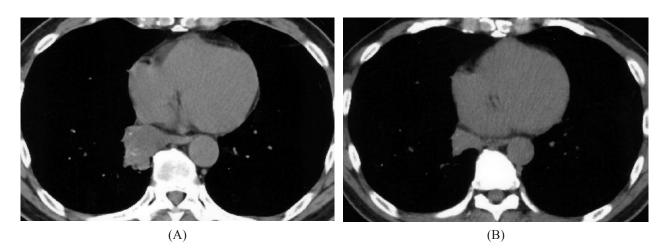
CT image taken in 2012, showing a retrocardiac lung mass, $4 \times 4.3 \times 3.4$ cm in size, with a cystic component and calcification in the axial section (A). CT image taken in 2008, showing a retrocardiac lung mass, $2.7 \times 2.9 \times 3$ cm in size.
